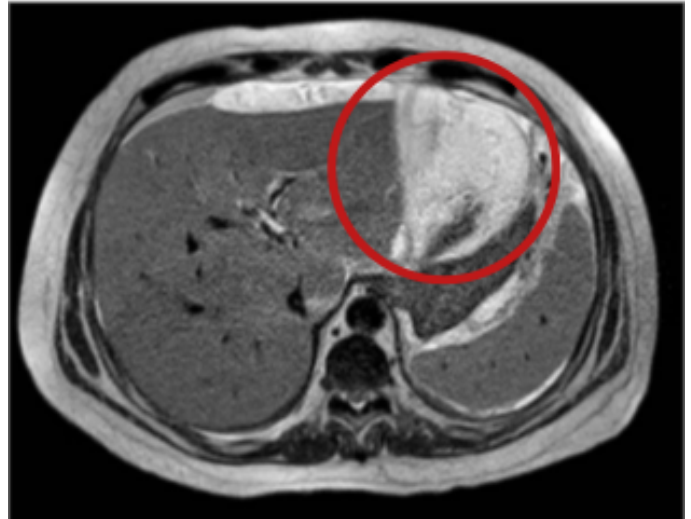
Non-contrast axial T2-weighted abdominal MRI demonstrating a peripancreatic collection with a thin, well-defined wall, heterogeneous peripancreatic tissue, and associated alteration in the morphology of the pancreatic tail.
